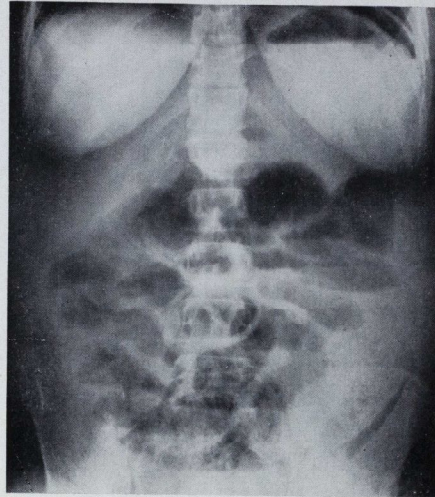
Erect A-P abdominal X-ray taken on admission showing gas bubbles in the uterus, and air under the left hemidiaphragm.
